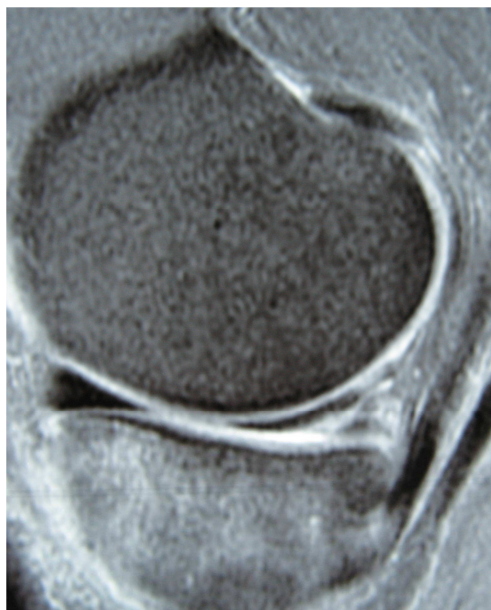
MRI (sagittal view T2 FS): grade3 degenerative meniscus lesion
